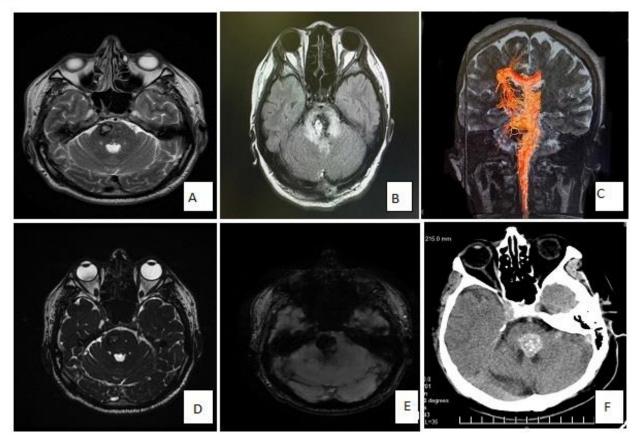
Interscopic diagnostic methods . a – MRI axial section T2, CM of the pons, b – MRI axial slice T1, CM with pontine hemorrhage, c – MR tractography, coronal slice, CM of the pons, d – MRI axial slice, CM of the bridge, FIESTA mode, e – MRI axial section, SWI mode, pontine cavernoma, (f) MSCT axial section, cavernoma with pontine hemorrhage.
